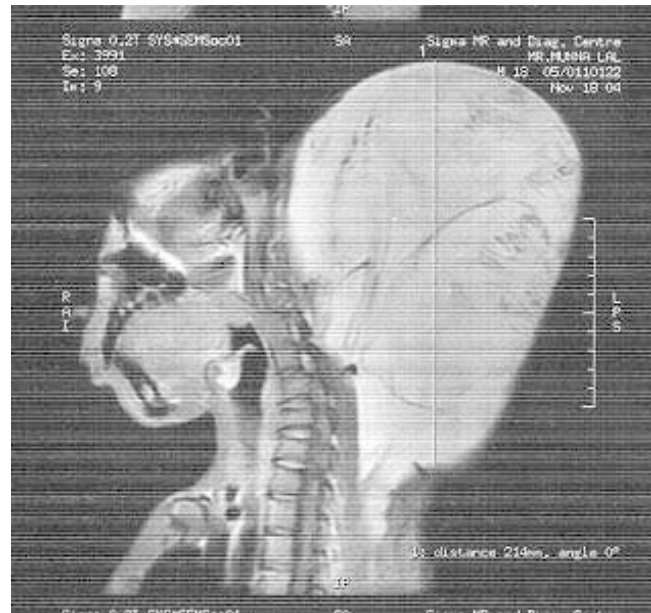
MRI showing extent of tumour.
